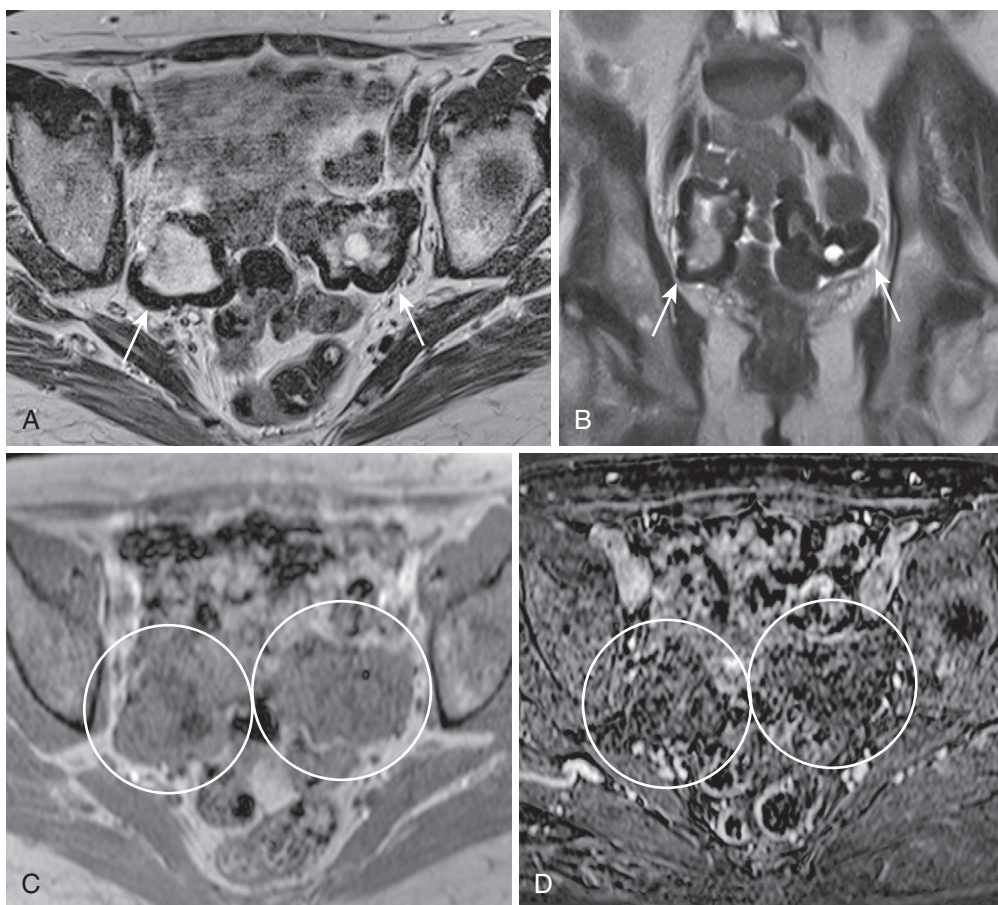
Bilateral fibromas. Serpiginous hypointensity (*arrows*) distorts the appearance of the ovaries bilaterally on axial (A) and coronal (B) T2-weighted images. C, Axial T1-weighted in-phase gradient echo image shows monotonous mild hypointensity to isointensity (*circles*), and signal characteristics most strongly suggest fibrous tissue. D, Mild bilateral enhancement (*circles*) is noted on the subtracted postcontrast image.
